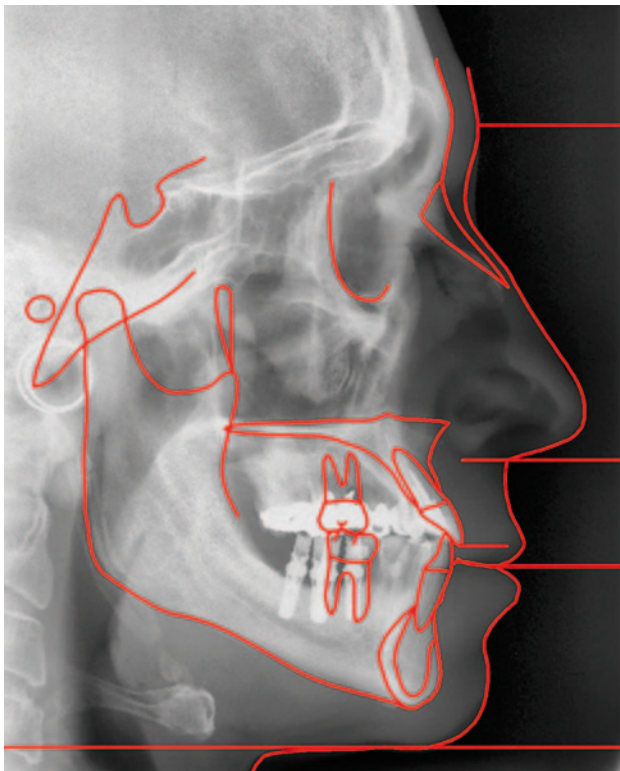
Post-treatment lateral cephalometric radiograph and tracing in maximum intercuspitation after orthodontic treatment
